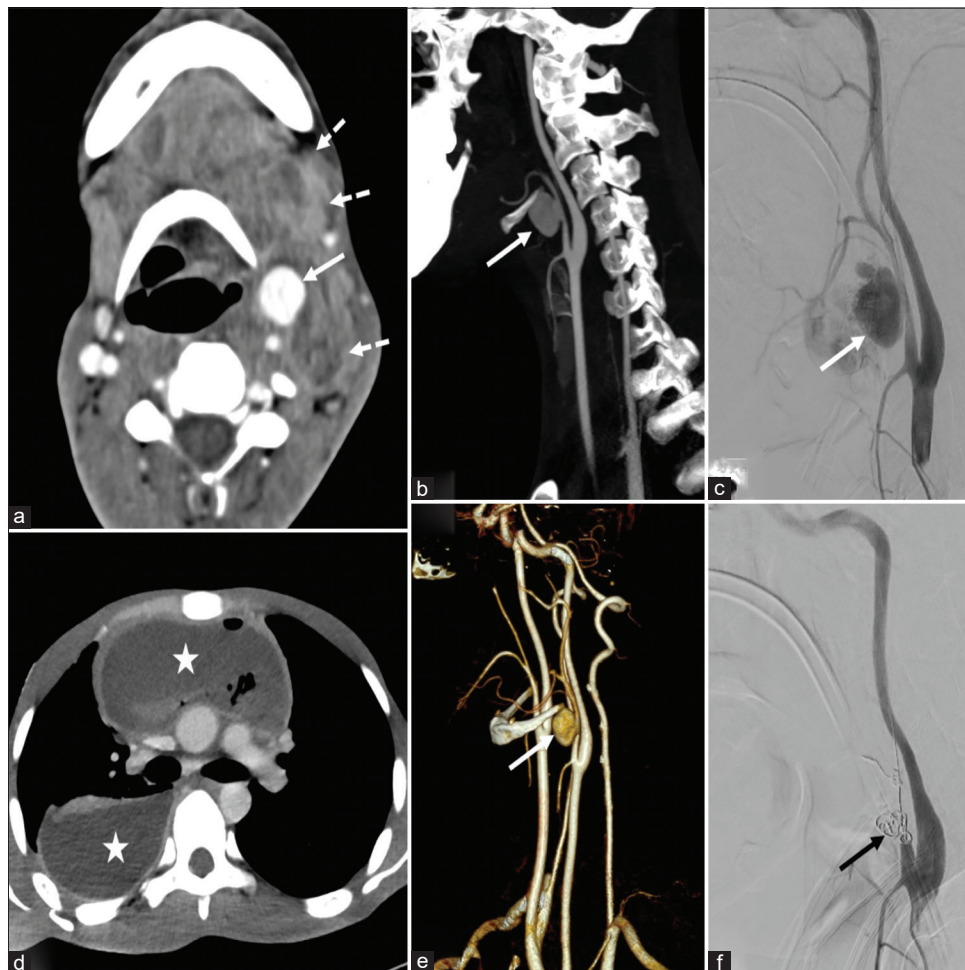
CT angiography (a-c and e) showing lobular pseudoaneurysm arising from the proximal part of ECA. (f) Postcoiling (black arrow) CCA angiogram showing no filling of the pseudoaneurysm (d) Axial CT image showing the loculated collection in the anterior mediastinum and right-sided pleural cavity. CT: Computed tomography, ECA: External carotid artery, CCA: Common carotid artery
